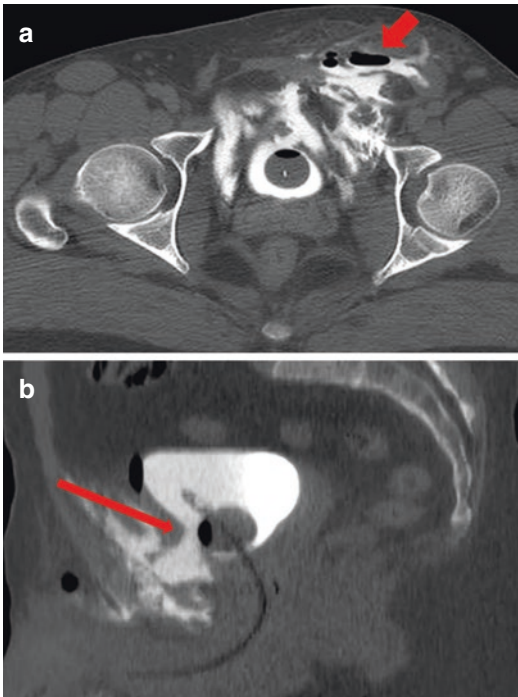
Urinary bladder extraperitoneal rupture; axial image (a) and sagittal reformatting (b) of a CT cystogram. Focal disruption of bladder floor in the anterior site (arrow) with diffuse contrast extravasation into the perivesical extraperitoneal space and in the anterior abdominal wall (short arrow); note the presence of gas bubbles
